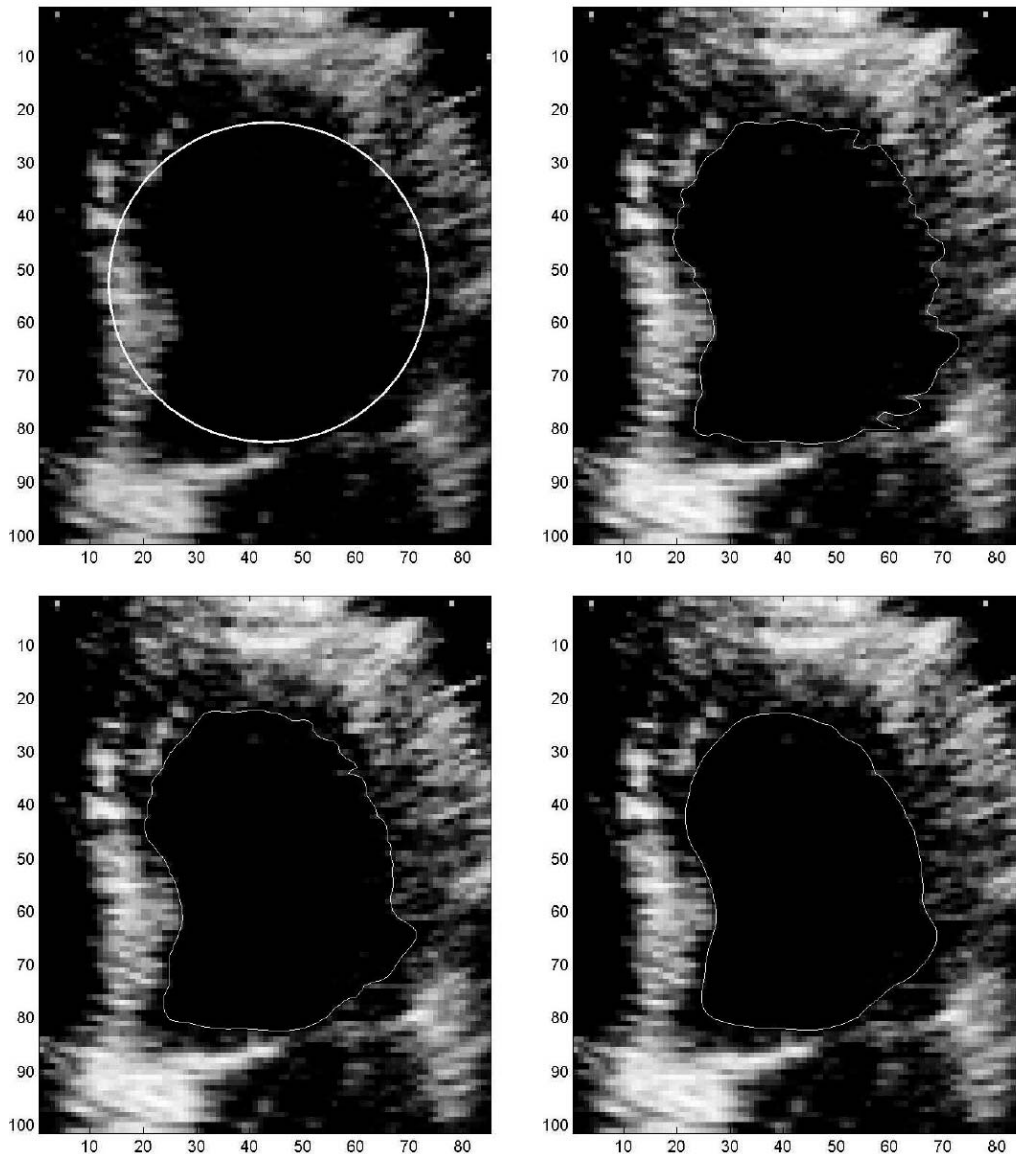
Initial condition (upper left) and some evolution steps of the segmentation of left ventricle from a typical echocardiographic four chamber view acquisition. The convergence was reached in 150 iterations.
